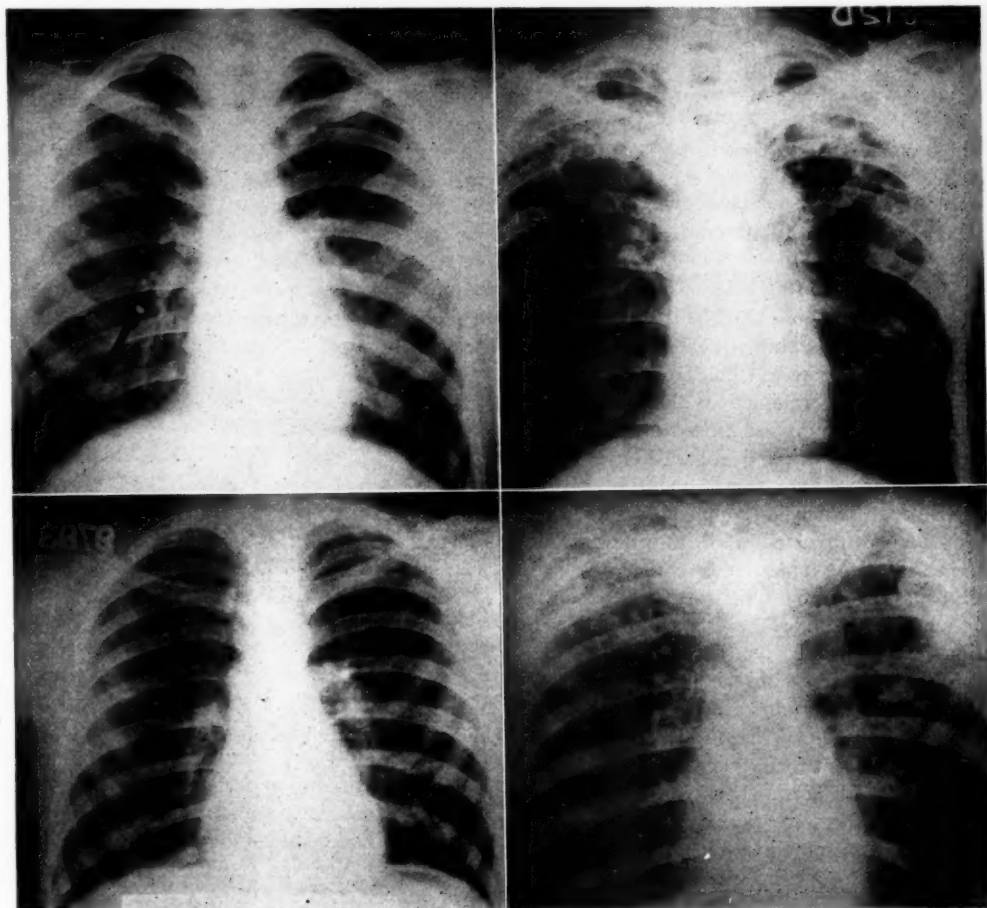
(upper left). H. P. X-ray film taken on September 19, 1924, of a boy of twelve years. Shows evidence of Ghon tubercle formation on the right side in the third interspace. No other abnormal shadows were seen. The tuberculin test was positive.
